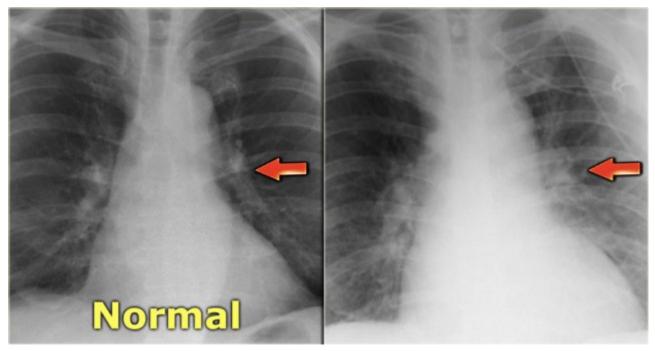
Chest X-ray of Heart Failure This image was downloaded from website https://radiologyassistant.nl
